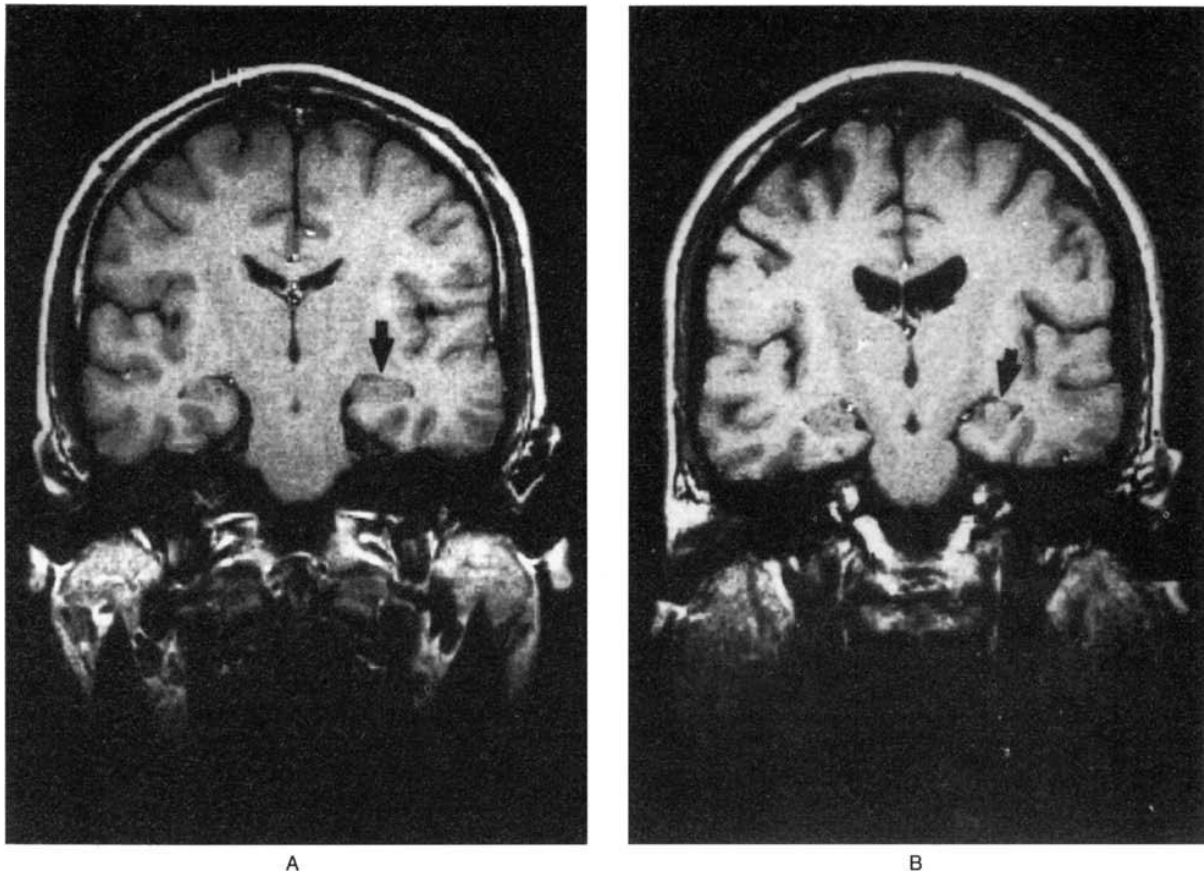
MRI Scans of the left and right hippocampus in a normal control (Panel A) and patient with schizophrenia (Panel B). The shape and size of the hippocampus, especially the left hippocampal area (arrows), are altered and the lateral ventricles are enlarged on both sides in the patient with schizophrenia (adapted from (12)).
